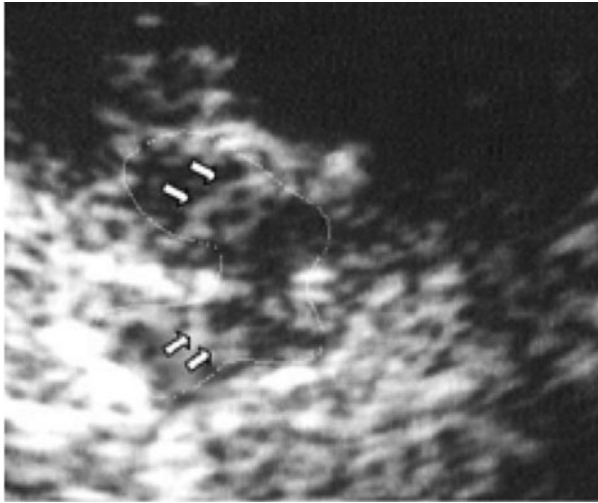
Transcranial sonography of the midbrain in a PD patient at baseline and 5 years later. No significant change in echogenicity has occurred despite deterioration of the patient. *Source:* Pictures courtesy of D. Berg from<sup>10</sup>.
